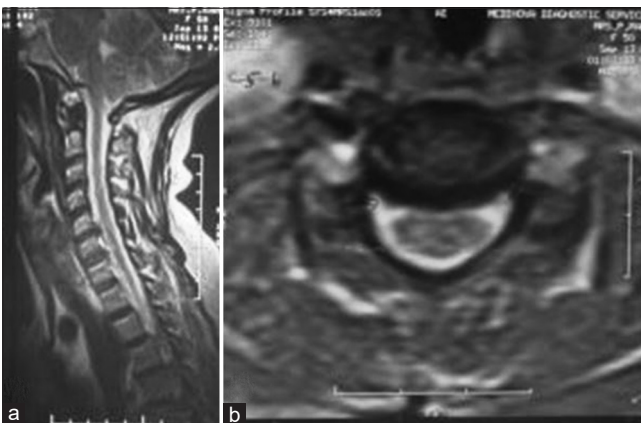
Showing sagittal (3a) and axial (3b) magnetic resonance imaging of the cervical spine with severe right C5–6 foraminal stenosis
